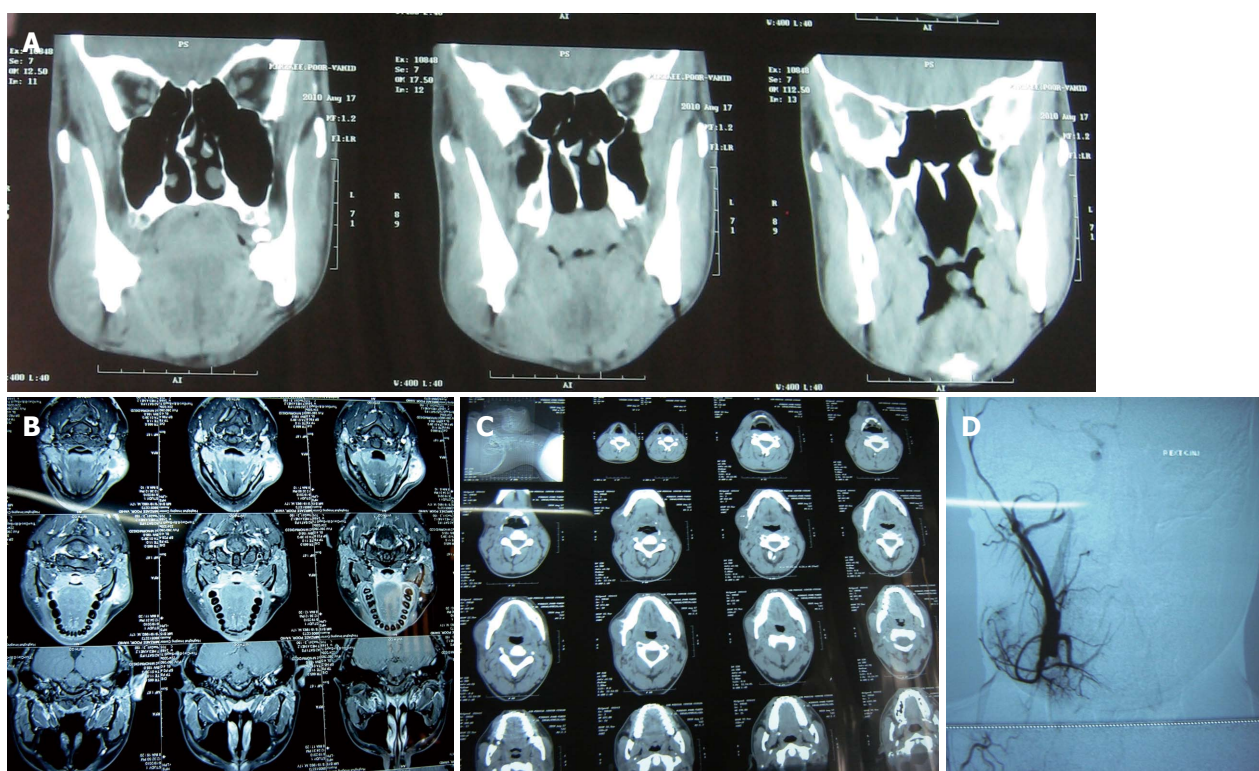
Computed tomography, magnetic resonance imaging and angiography. A: Coronal-axial computed tomography scan showed a lesion appeared to have a non-uniform intra lesional; B: Magnetic resonance imaging (MRI), T1 post contrast view demonstrated a well defined lesion with high signal intensity in the superficial part of right mandibular body and angle; C: MRI, T2 post contrast view demonstrated a well defined lesion with high signal intensity in the superficial part of right mandibular body and angle; D: Angiography of right carotid artery showed a lesion with only mild to moderate vascularity and ruled out arteriovenous malformation and hemangioma.
